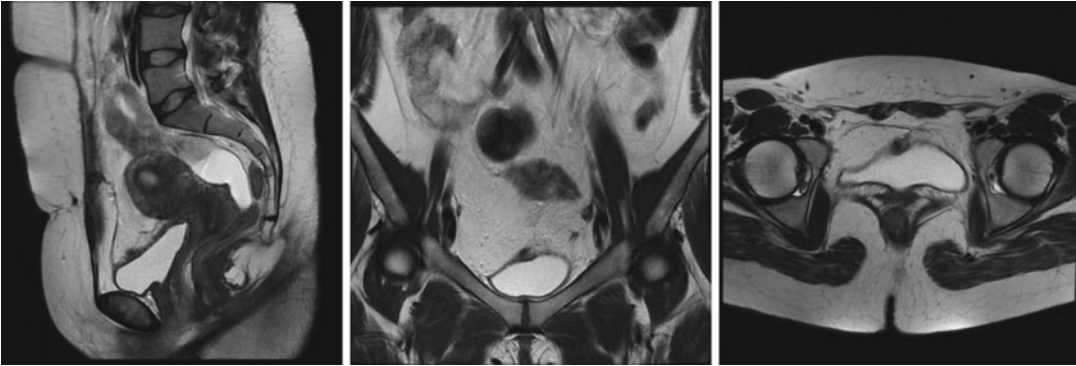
MRI shows a urachal cyst in the paramedian, in contact with the bladder dome; there are no signs of disruption of the bladder wall
